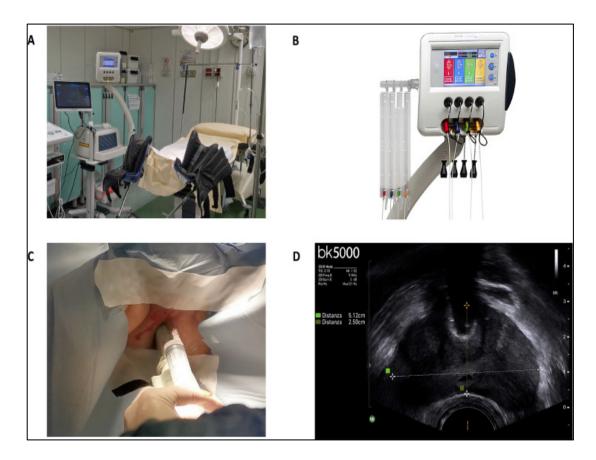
(a) Outpatient clinic setting. (b) Multisource solid state diode laser generator with four independent channels for multi-fiber lasing approach. (c) Perineal and periprostatic local anesthesia. (d) Transrectal ultrasound guided prostate gland measure.
